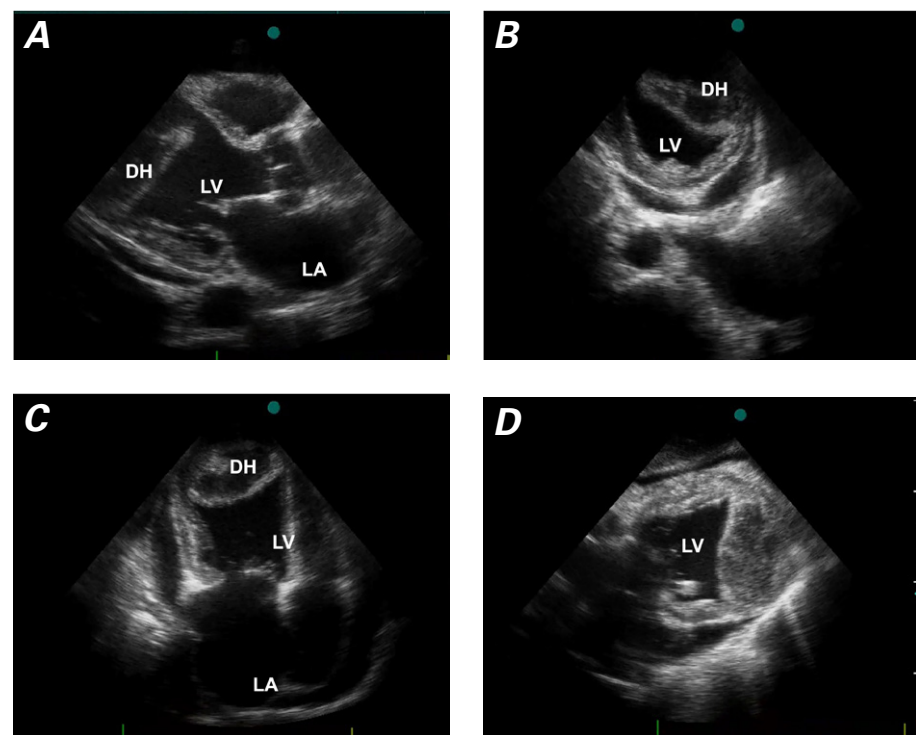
Two-dimensional echocardiograms show the intramyocardial dissecting hematoma. Para-sternal A) long- and B) short-axis views show the dissecting, echo-free cavity. C) The 4-chamber view shows the hematoma in the left ventricular apex. D) The subcostal long-axis view reveals increased echogenicity within the cavity, consistent with partially organized thrombi.
